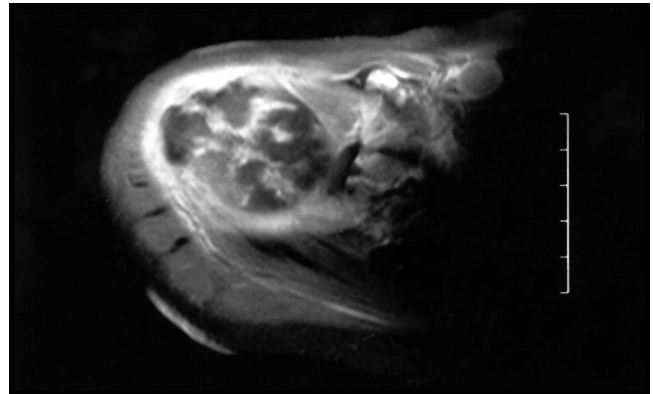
Magnetic resonance imaging of the right shoulder showing high signal intensity leukemic infiltration of the proximal humerus, synovium, and soft tissue around the joint associated with joint effusion.
